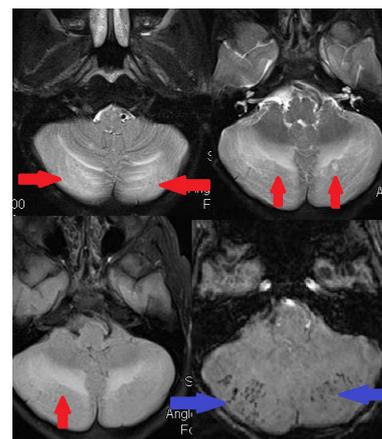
Haemorrhagic PRES – Axial FLAIR and GRE images showing FLAIR hyperintense signal involving bilateral cerebellar hemisphere and fissures (red arrow) with foci of susceptibility on GRE images (blue arrow).
